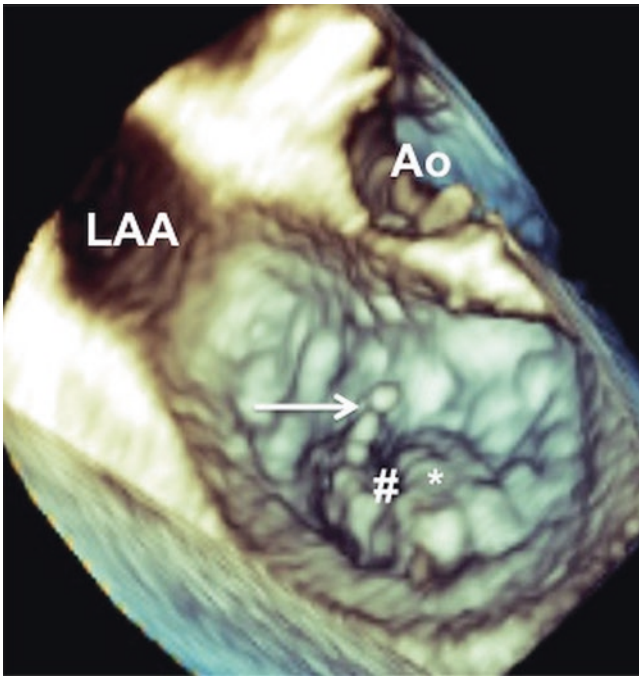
Volume rendered transthoracic 3DE data set of the mitral valve in a patient with P2 flail (\*) and ruptured chords (arrow). *Left panel*, *en face* view from the atrial perspective (Video 9.4a Left). *Right*
